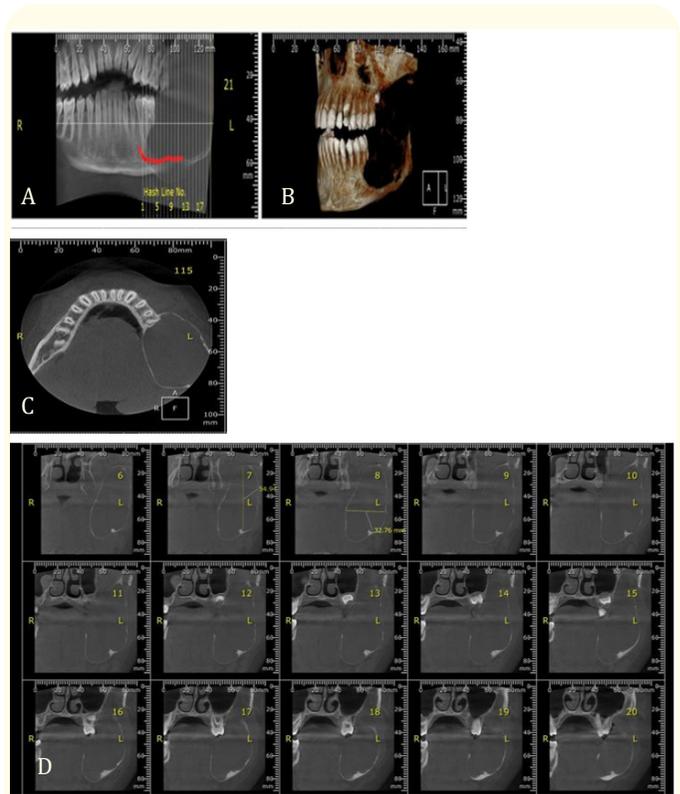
CBCT images A: panorama view with 10-mm slice thickness, B: 3D reconstruction showing destruction part of the mandible, C: Axial view, D: cross sectional view with 2-mm slice thickness revealed a bilocular radiolucent lesion that extended from the pre-molar region to the posterior border of ramus. Severe expansion and Thinning of the buccal and lingual cortical plates, root resorptions of 36Tooth was seen, Note an incomplete internal septum within the lesion, Perforation of the buccal and lingual cortex of the lesion is also shown.
